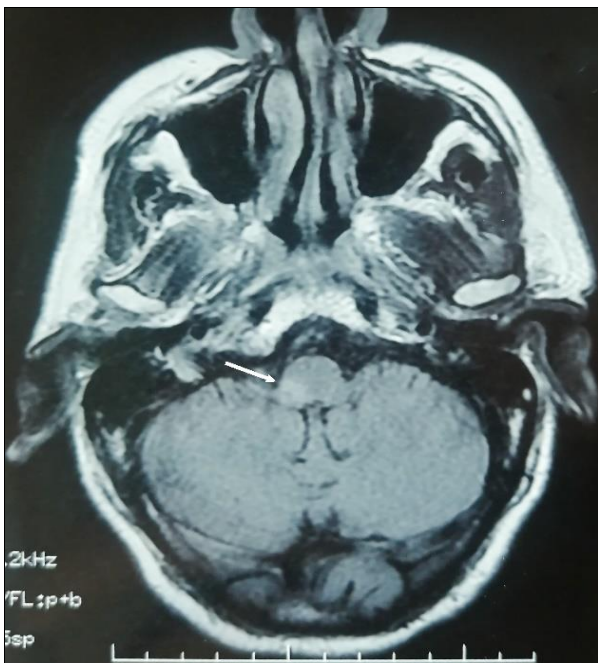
Axial FLAIR sequence of cerebral MRI showing acute infarct involving the right lateral part of medulla (white arrow).
